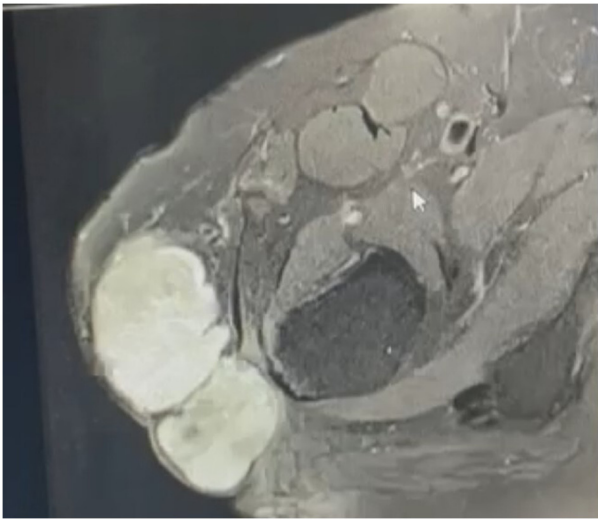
MRI axial view of the tumor (2020). MRI, magnetic resonance imaging.
